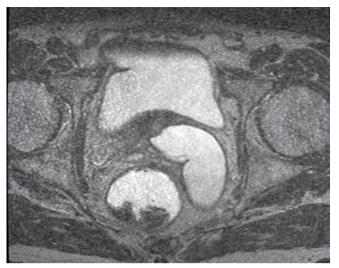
Magnetic resonance imaging conducted after the puncture procedure, aspiration of the dense purulent material from the left ectopic ureter and lavage with an amikacin solution. An axial scan performed at the level of the base of the prostate gland presents a narrowing segment of the ectopic ureter that goes beyond the midline to enter the prostatic urethra between the seminal colliculus and the neck of the urinary bladder on the right side
